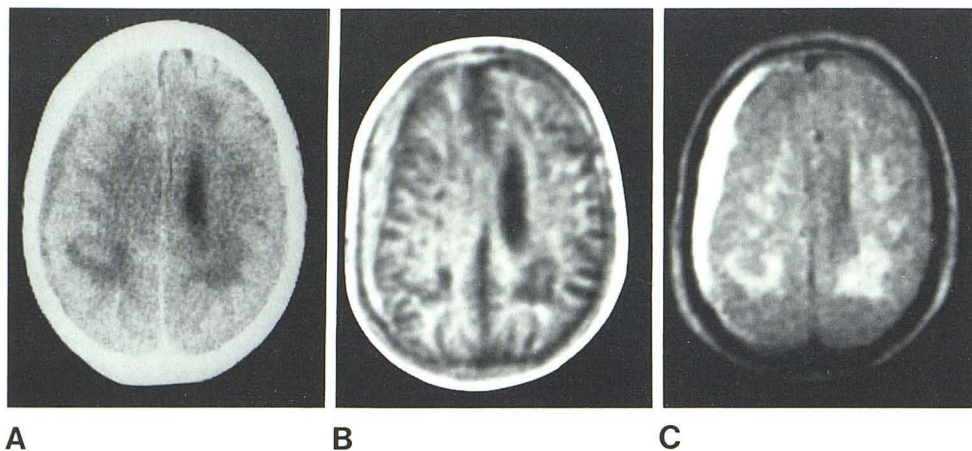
Subdural hemorrhage. A, CT. B, IR_{1400/400}. C, SE_{1080/40}. Hemorrhage demonstrated on all three scans.
